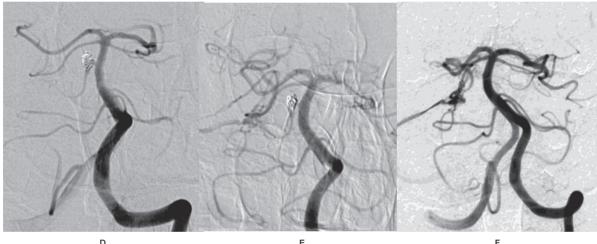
MPB dissecting aneurysm (Case 5). A) CT showing SAH mainly in the right ambient cistern. B,C) CTA and DSA showing an aneurysm at the origin of the right pontine branch of the basilar artery. D) DSA showing embolized aneurysm and patent parent artery was preserved. E) Follow-up DSA showing preserved MPB and AVM. F) DSA showing AVM with Onyx embolization and complete occlusion of parent artery with coils in the 2nd stage.
